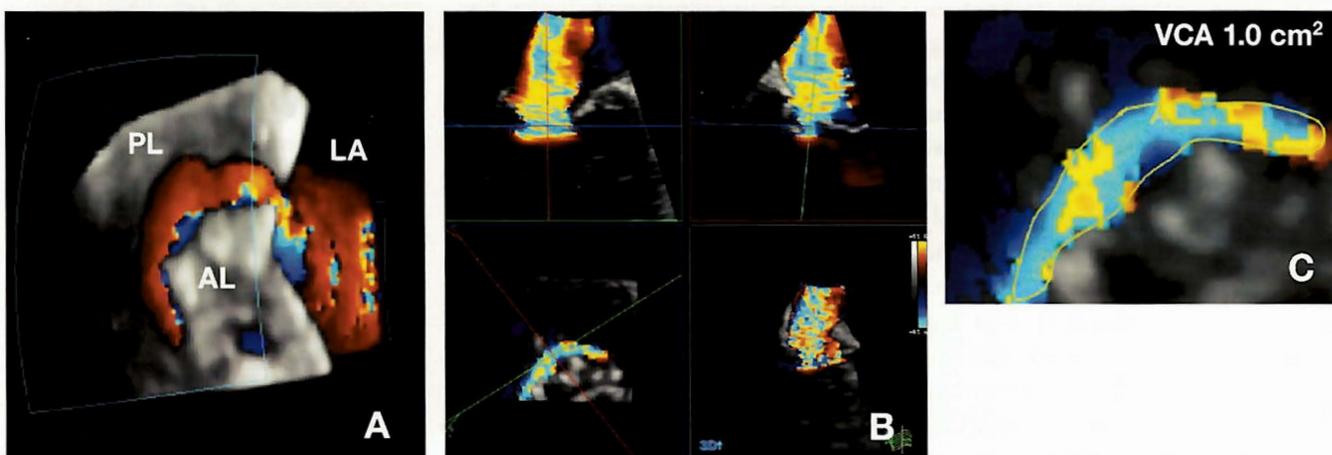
3D color Doppler for the quantification of asymmetric regurgitant flow. Panel A shows the crescent-shaped proximal flow convergence zone created by an extensive coaptation defect in "functional" mitral regurgitation. The 3D color Doppler data is cropped to reveal the true short-axis of the vena contracta zone (panel B, upper images are long-axis views, lower left is short-axis). The highly asymmetric vena contracta (VG) area is traced to provide a quantitative measure of MR severity. In this case the VC area is 1.0 cm², which is consistent with severe MR (panel C, zoomed image of lower-left image in B).
